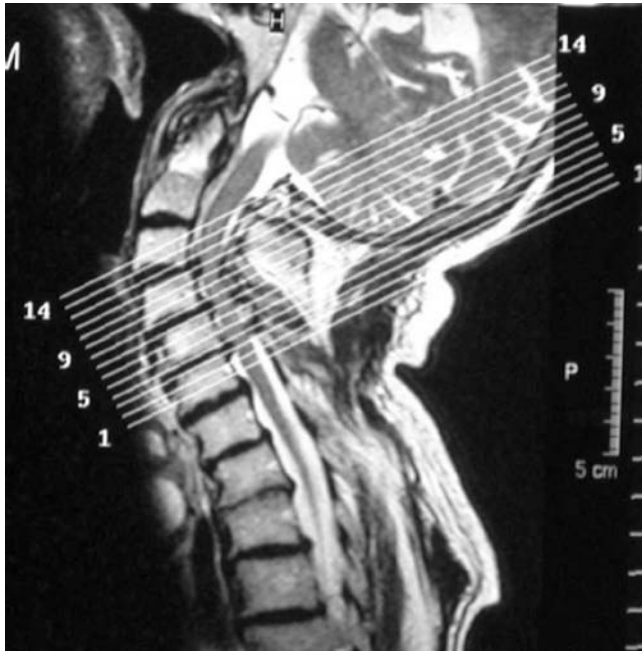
Magnetic resonance imaging of a patient with painful cervical dystonia and cervicogenic headache showing defective posture of neck and head due to muscular hyperactivity. From Reichel G. Botulinumtoxin in der Therapie schmerzhafter fokaler und segmentaler Dystonien. In: Göbel H, ed. *Botulinum toxin A in der speziellen Schmerztherapie*. Uni-Med-Verlag: Bremen, 2004, with permission.
